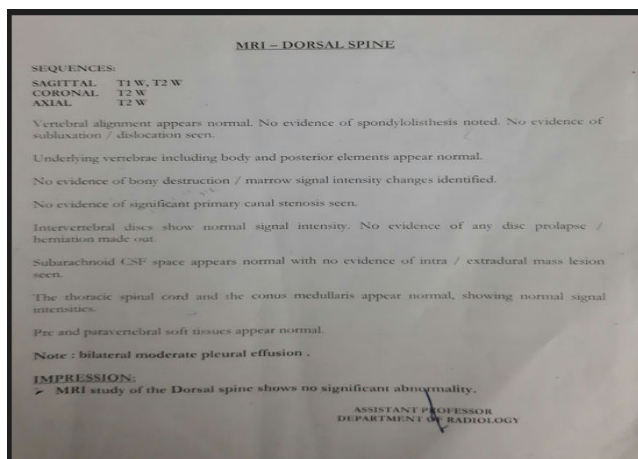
Laboratory investigations and MRI findings a diagnosis of Guillain-Barré syndrome.
